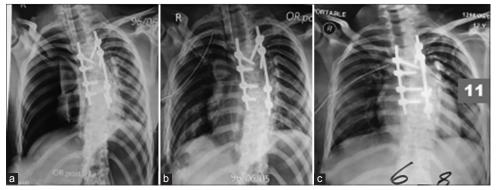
Intra and post-operative portable chest X-rays; (a) OR - X-ray shows right-sided TPT and shrinkage of right lung (white arrows), (b) X-ray in OR, with a chest tube, the right lung is shrunken yet (white arrows), the tip of the chest tube is kinked, but a few minutes later, it was replaced; (c) a few days later, the lung is expanded and no pneumothorax is seen.
